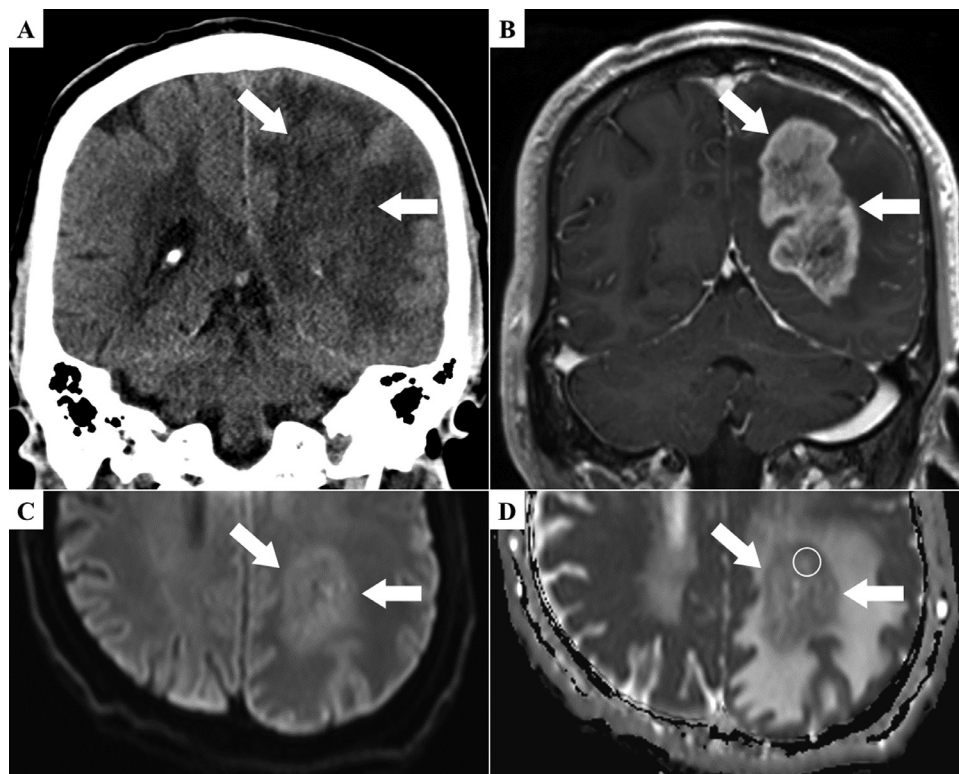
Imaging obtained before steroid administration. (A) Non-contrast-enhanced CT shows a heterogeneous lesion in the left temporal, occipital, and parietal lobes (arrows). (B) Contrast-enhanced T1-weighted MRI shows a mass lesion with irregular contrast enhancement accompanied by vascular development (arrows) and perifocal edema. (C, D) DWI shows slightly restricted diffusion (arrows), with an apparent diffusion coefficient (ADC) of $1.128 \times 10^{-3} \text{ mm}^2/\text{s}$ (circle).
